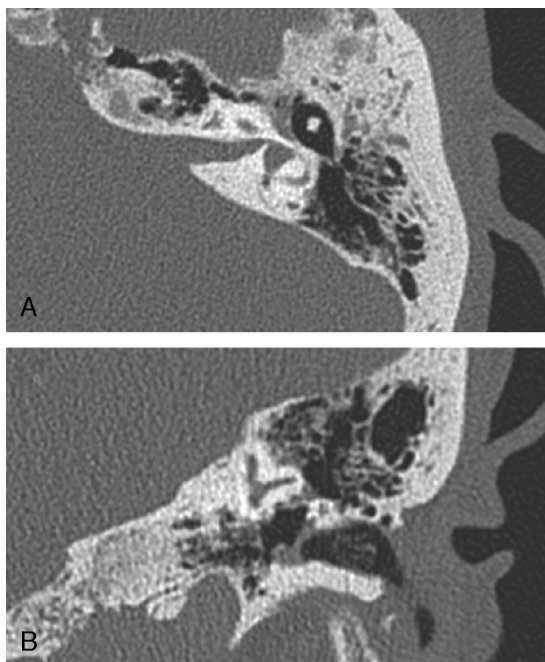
Axial (A) and coronal (B) CT scan of the contralateral ear reveal normal anatomy.
